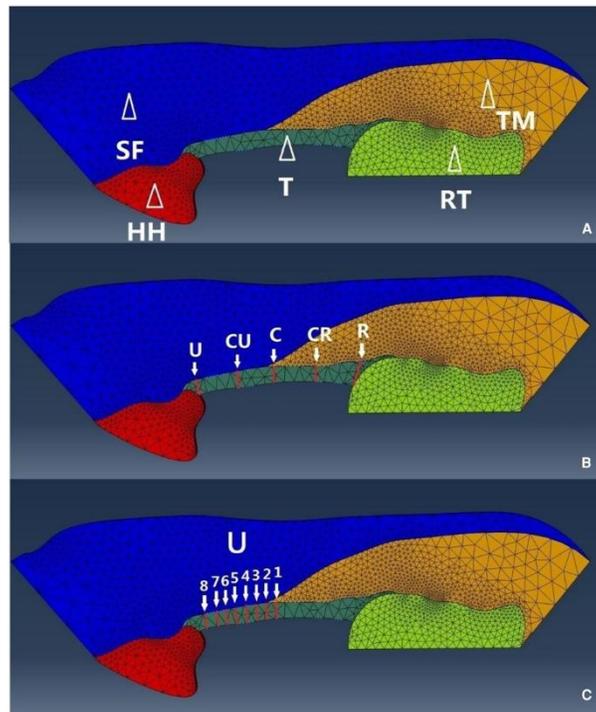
(a) Based on an ultrasound scan, the FE model of the volar carpal tunnel (b) Transection position on the TCL denoted as U, ulnar; CU, central-ulnar; C, central; CR, central-radial and R, radial (c) On the ulnar half of the TCL, the transection location is designated from 1 to 8.[18]
